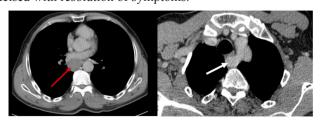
An enhanced thoracic CT scan (axial) showing a cystic formation located in the posterior mediastinum and noted along the right side of the lower portion of the thoracic esophagus
